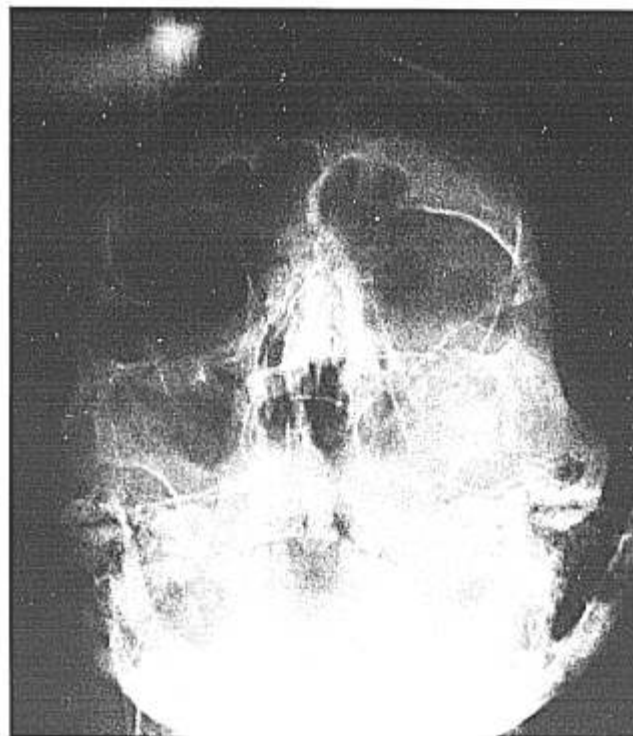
Preoperative roentgenogram, demonstrating the fractured sites: 1) bilateral ethmoidal fractures; 2) nasal-bone fractures; 3) right maxillary bone fractures.
